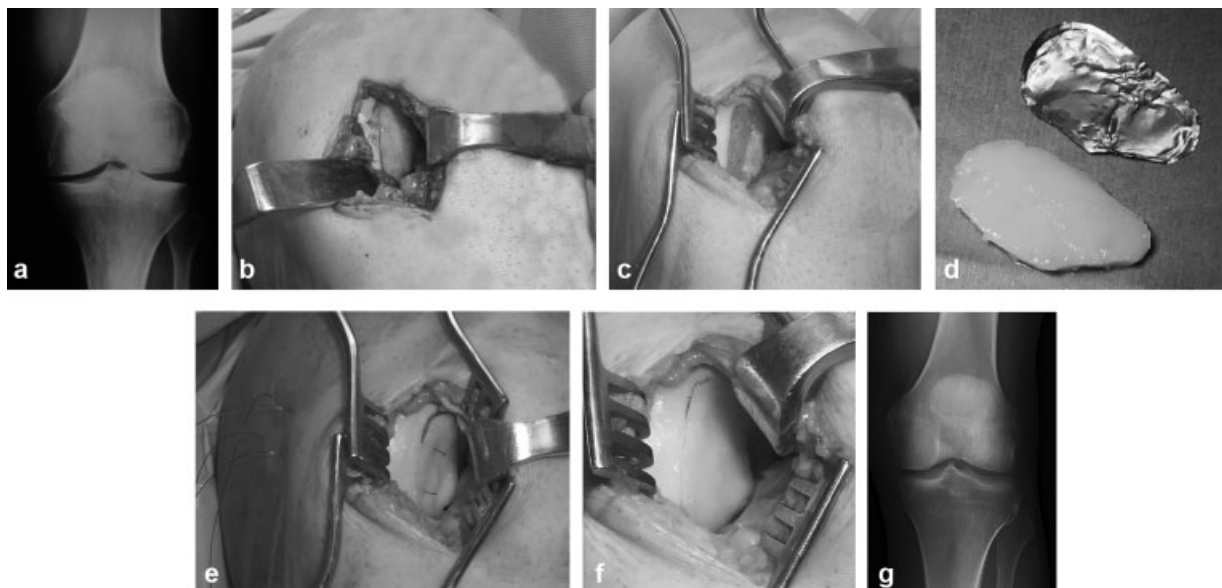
(a) Preoperative X-ray, (b) An arthrotomy was performed and the injured area was exposed. (c) Loose osteochondral fragments were removed and the scar tissue in the bed of the lesion was curetted and small perforations were made in the subchondral bone plaque, without removing it, so that the biological glue would facilitate the anchoring of the bone implant. (d) An aluminum template to build a mold of the same morphology as the injury was used, (e) sutures were switched for re-absorbable sutures. (f) Once the implant had been placed, the transosseous sutures were removed, and a layer of fibrin glue was injected on the joint surface of the graft, (g) 12 months control X-ray.
